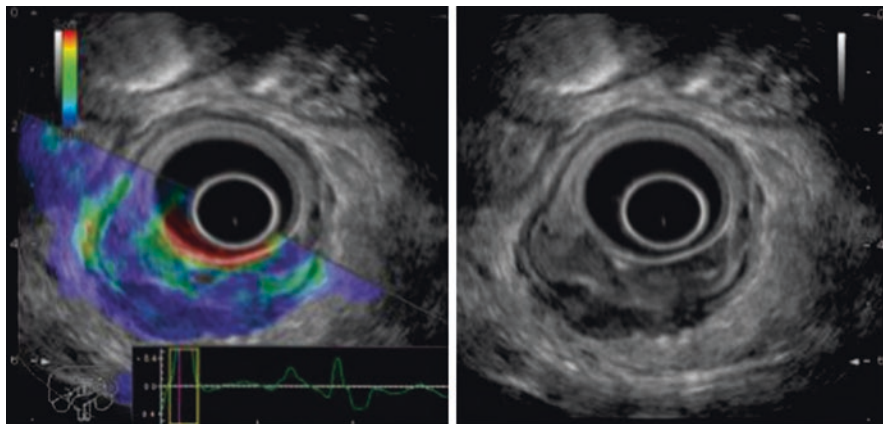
Endoscopic ultrasonography elastography image of a rectal adenocarcinoma with a predominantly blue pattern indicating a low strain mass (left side real-time sono-elastography mode, right side B mode; (World J Gastroenterol. Feb 7, 2016; 22(5): 1756–1766)).
